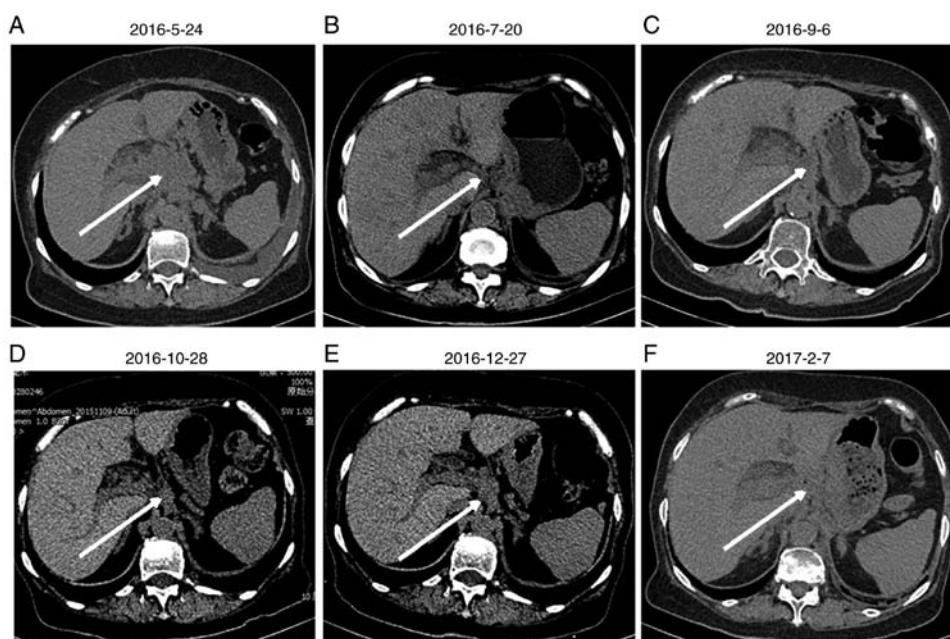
Abdominal computed tomography scans of the patient. Images were collected on (A) 2016-5-24, (B) 2016-7-20, (C) 2016-9-6, (D) 2016-10-28, (E) 2016-12-27 and (F) 2017-2-7. The arrows indicate the location of the tumor.
